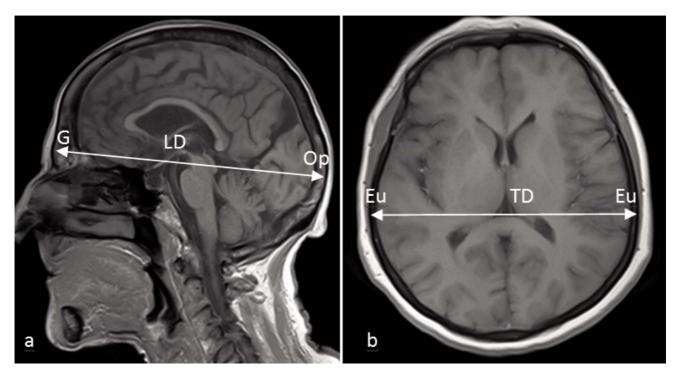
MRI of a head: a) Sagittal head and neck: LD - the distance from the glabella (G) to the opisthocranium (OP); b) Axial head: TD - the distance from euryon to euryon (EU-EU).
